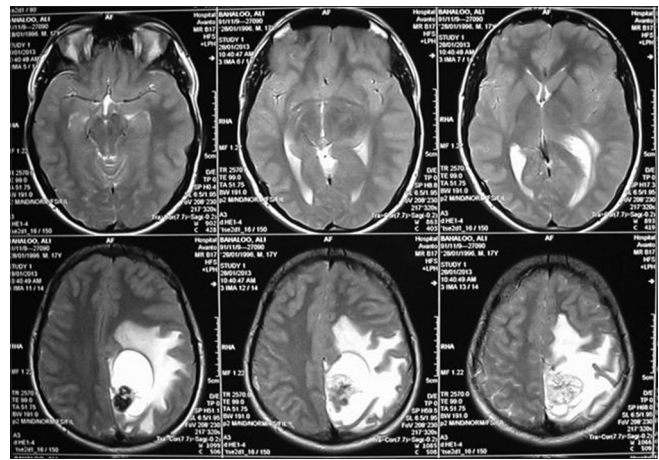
T2 MR images of the patient showing a cyst with mural nodule in the left parieto-occipital region with prominent edema
